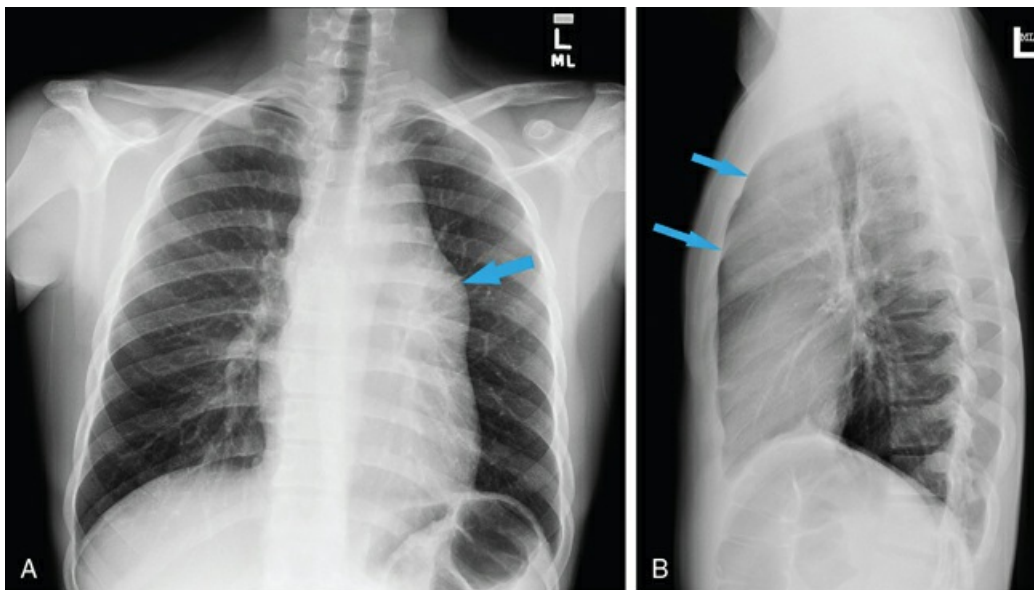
Chest radiographs of patient with large mediastinal mass shown in posteroanterior (A) and lateral (B) views. The mass, proved at surgery to be a germ cell tumor (seminoma), involves anterior and middle mediastinal compartments. In (A), the mass is above the left heart border, including the bulge in the area of the left hilum (arrow). In (B), the mass occupies the retrosternal space above the heart, which normally should have air rather than soft tissue (arrows).
